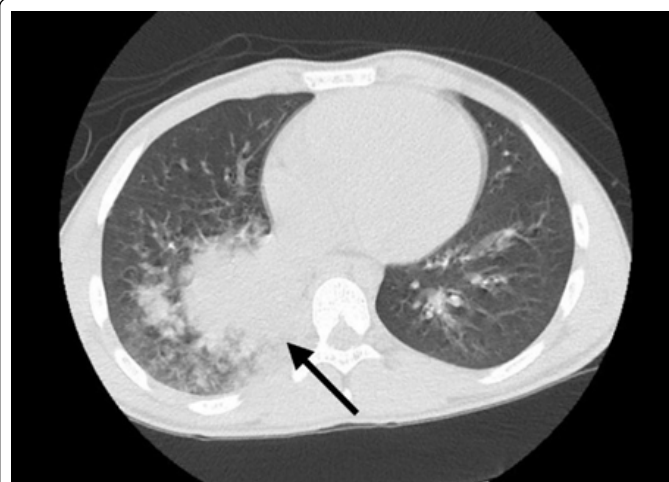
Admission CT-ICU: Consolidative opacity affecting the right lower lobe, with adjacent ground-glass opacities.
